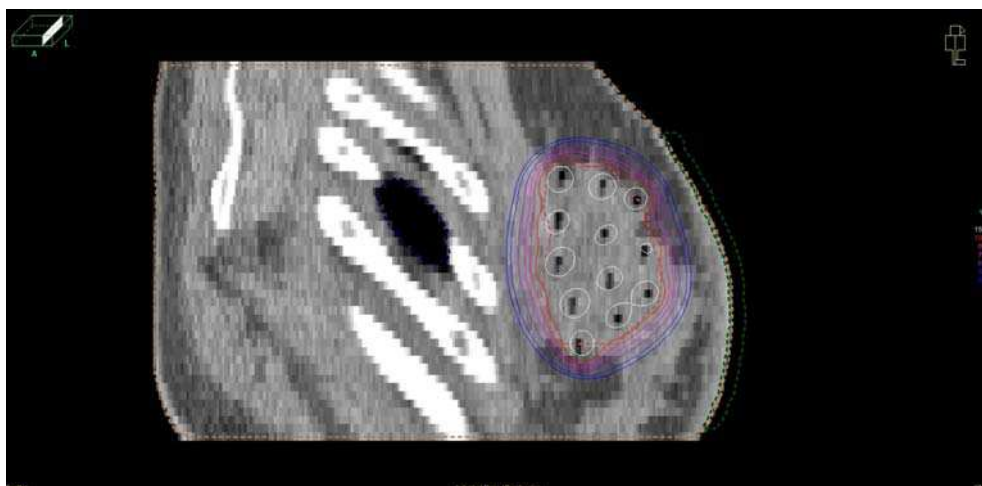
Breast cancer - Saggital CT scan makes possible assessment of distance from ribs (white structures) and applicators, also from skin to applicators. Values of isodoses are visible.
